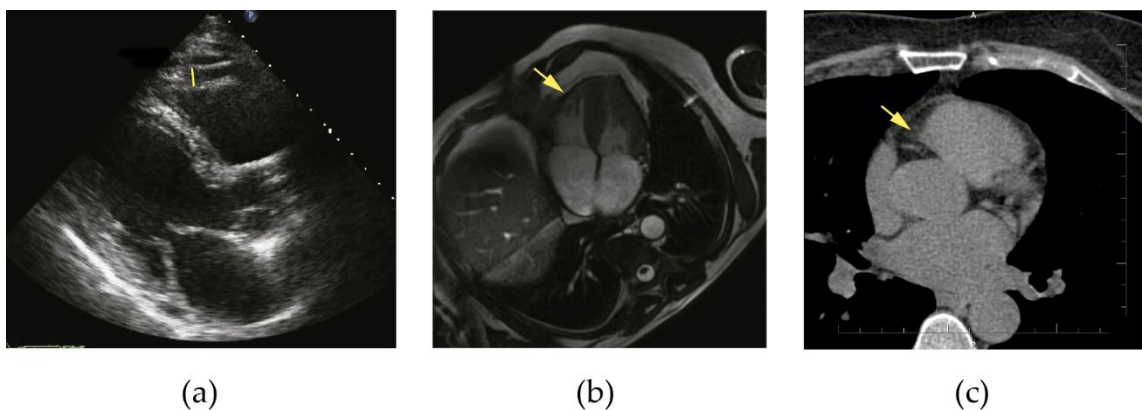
Images of non-invasive imaging techniques for epicardial fat assessment. Echocardiography (a) with marked epicardial fat thickness. Cardiac magnetic resonance (b) and computed tomography (c) images. The yellow arrows indicate epicardial fat.
